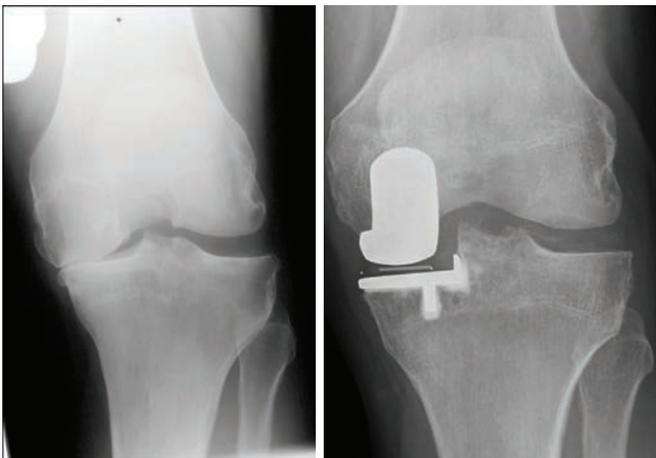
X-rays of a good candidate for partial knee replacement. (Left) Severe osteoarthritis limited to the medial compartment. (Right) The same knee after partial knee replacement. source: /www.orthoinfo.aaos.org/en/treatment/unicompartmental-knee-replacement
